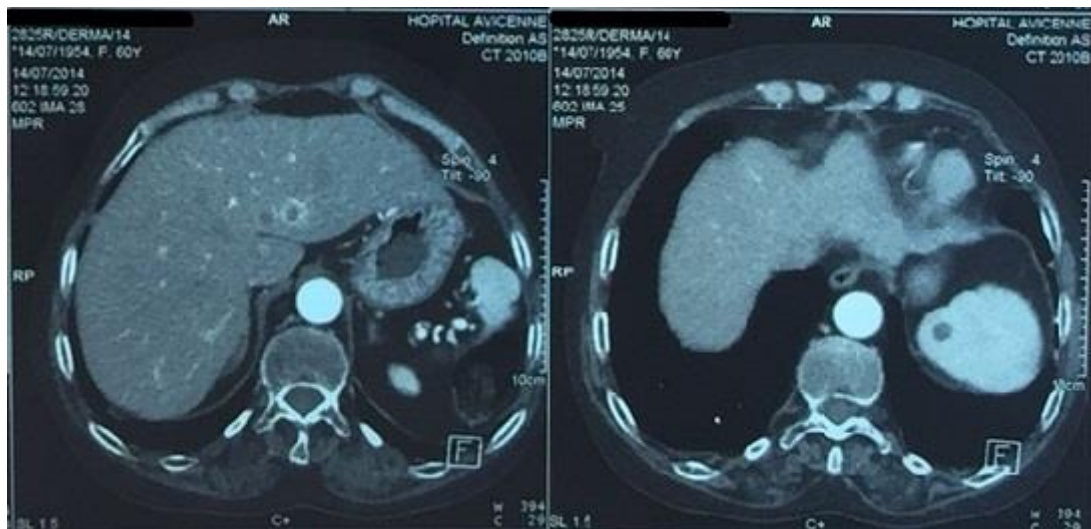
a,b. (a) Abdominal CT: axial section after contrast injection in the arterial phase, showing hypodense hepatic lesions of the segment III with ring enhancement. (b) Abdominal CT: axial section after contrast injection in the arterial phase, showing a hypodense splenic lesions
